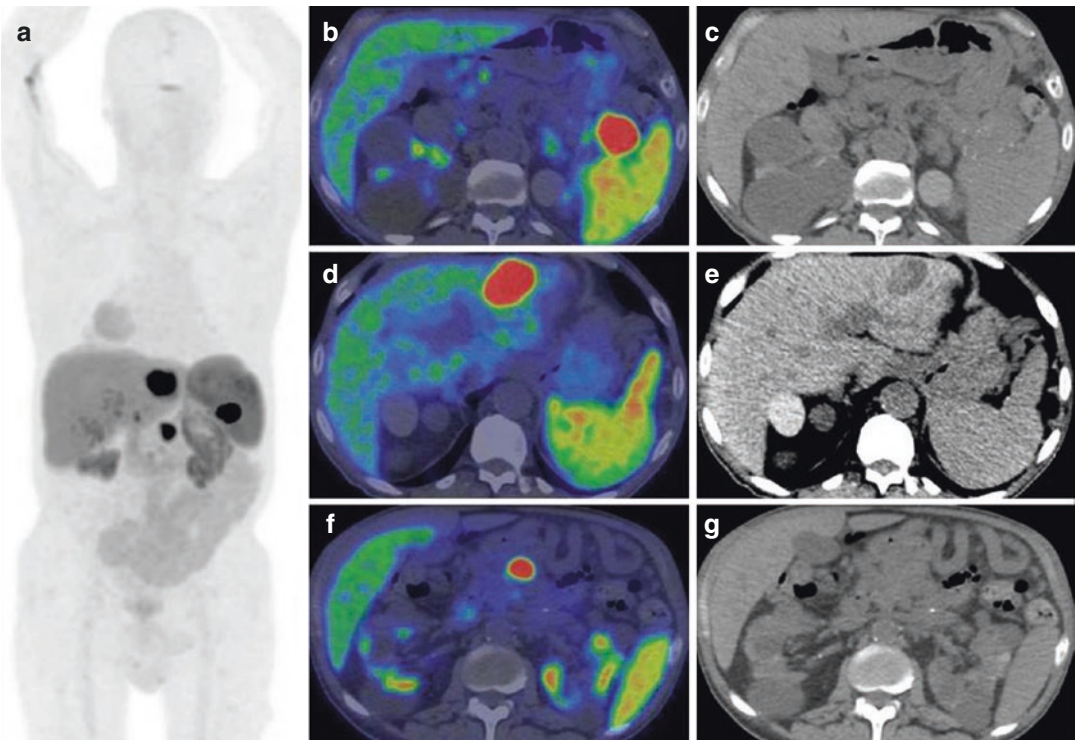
This figure summarizes findings in a 63-year-old patient examined by ⁶⁴Cu-DOTANOC PET/CT for staging NET of the pancreas. ⁶⁴Cu-DOTANOC PET 3D maximum intensity projection (a) shows three areas of intense uptake in the upper abdomen, corresponding to a
